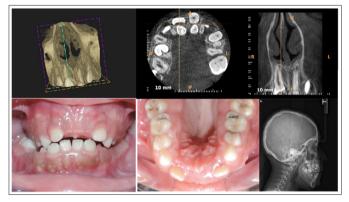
An example of a case of impacted maxillary central incisors in 10 Y.O. female patient. The CBCT, and Cephalogram help in deciding the location of the impacted teeth. What is the first step in making the appropriate diagnosis.
